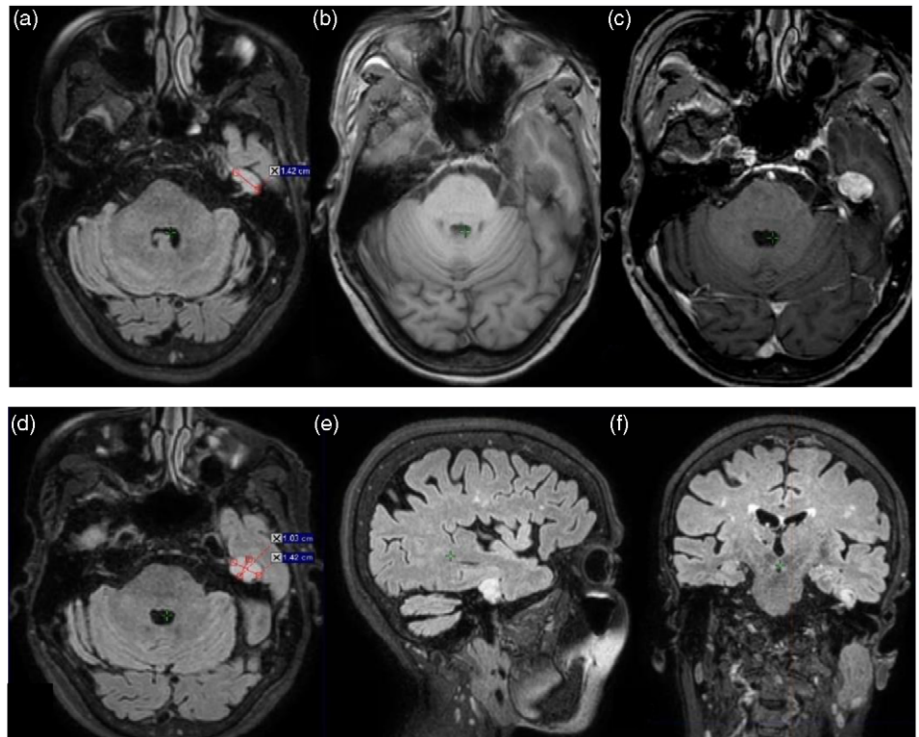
(a) Axial FLAIR images demonstrating an oval-shaped lesion centred on the tract of VII nerve and the left geniculate ganglion. (b) Axial T1-weighted images showing the lesion with low signal intensity. (c) Axial post-contrast showing the well-defined lesion with intense and homogenous enhancement. (d) Axial, (e) sagittal and (f) coronal FLAIR images showing the tract of the left facial nerve and the geniculate ganglion in close contact with the ipsilateral oval-shaped hyperintense lesion.
